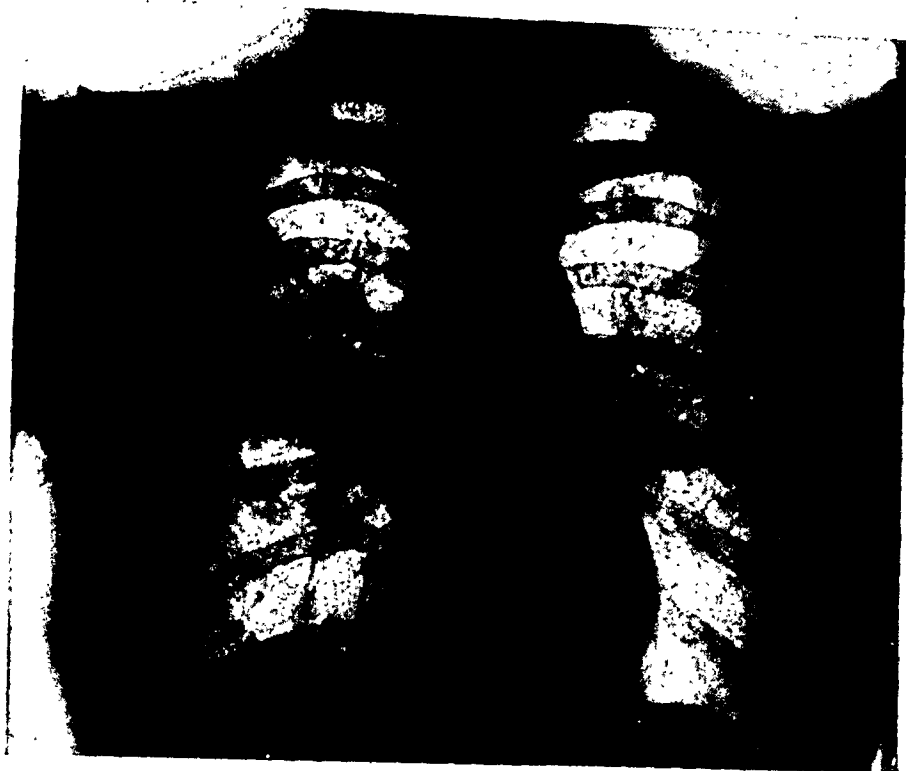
Case 4. Roentgen photograph of the thorax 2/2—39. Typical Boeck's sarcoid in the lungs.
